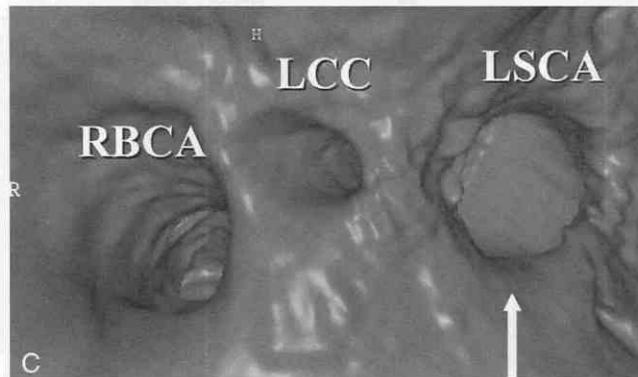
A, Sagittal oblique multislice CT scan shows aneurysmal dilatation of the subclavian artery with surrounding thrombus (arrow). B, Coronal volume-rendered CT scan demonstrates aneurysmal involvement of the transverse arch (A) and left subclavian artery (arrow). C, Virtual endoscopic image of the aortic arch shows relative aneurysmal dilatation of the subclavian artery (arrow). LCC = left common carotid artery; LSCA = left subclavian artery; RBCA = right brachiocephalic artery.
